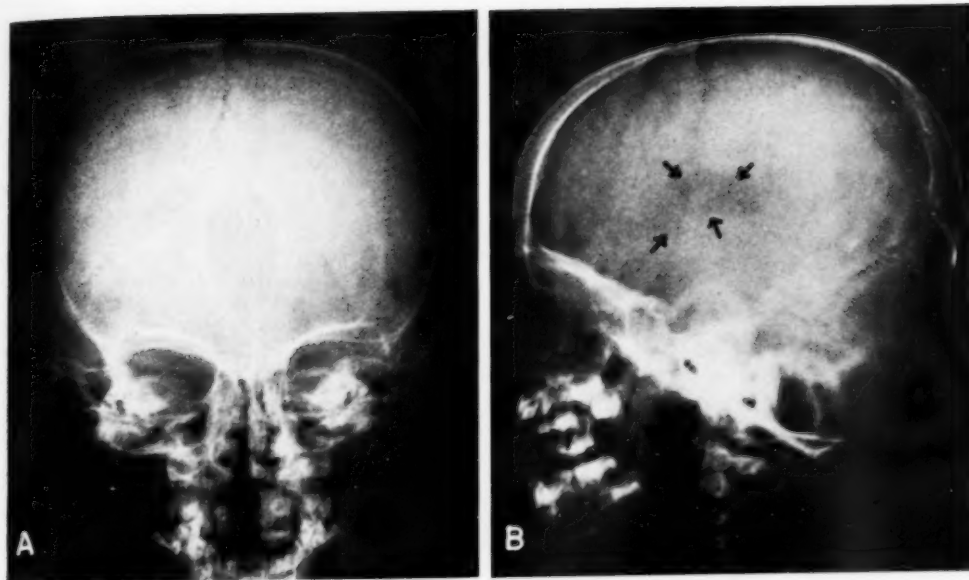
Lipoma of corpus callosum: plain roentgenograms of skull. A. Postero-anterior view showing mid-line radiolucent area outlined by thin lines of calcification. B. Lateral view revealing ovoid radiolucent area. (On original films several small flecks of calcification were visible.)
